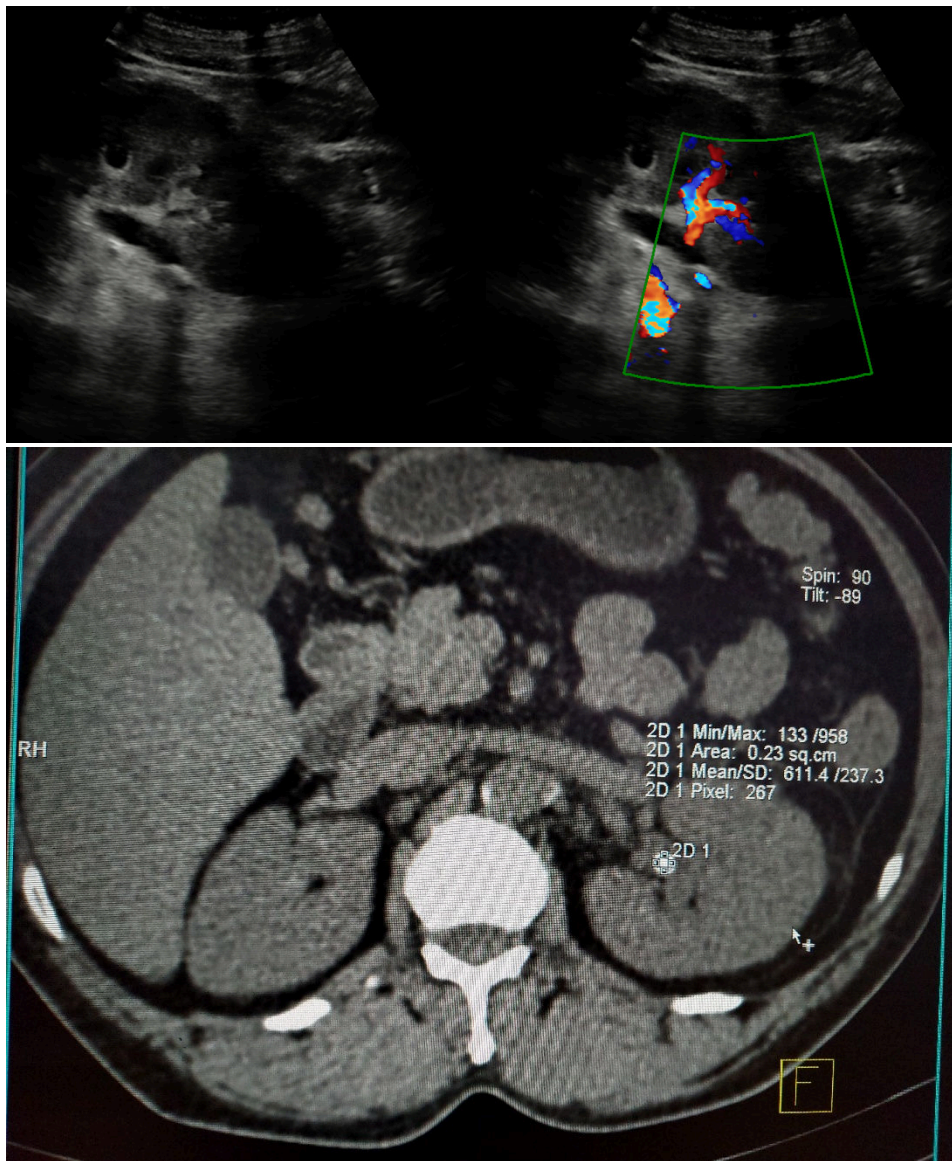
Figure III (A, B): US (grey scale and colour doppler) as well as non-contrast CT showing calculus in the left renal pelvis which shows grade 2 twinkling artifact on doppler with mean HU of 611.
